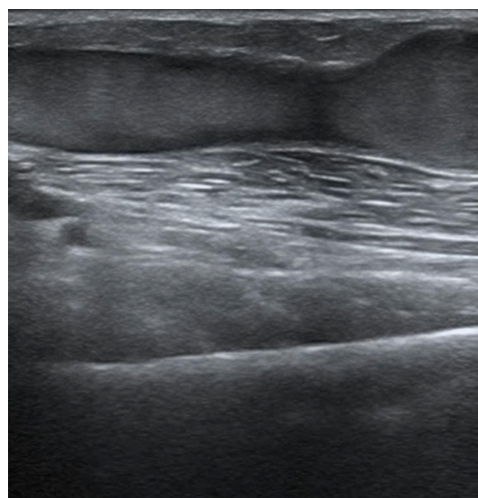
Ultrasound image of the fistula vessel at the end of thrombolysis.
